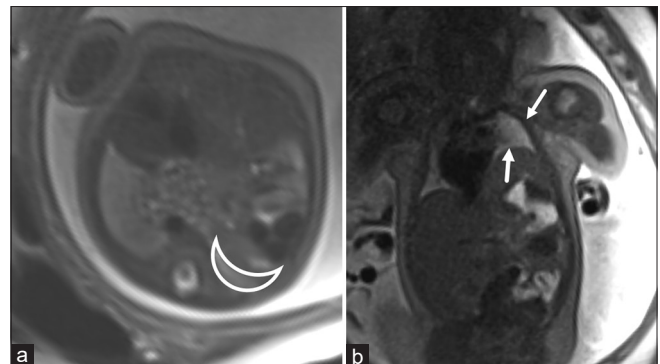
(a) Axial T2 image from fetal magnetic resonance imaging demonstrates a hypoplastic right lung (white crescent outline) in the setting of a right congenital diaphragmatic hernia. (b) Coronal T2 image from fetal magnetic resonance imaging in a different patient shows a left congenital diaphragmatic hernia with a hypoplastic left lung (white arrows)
